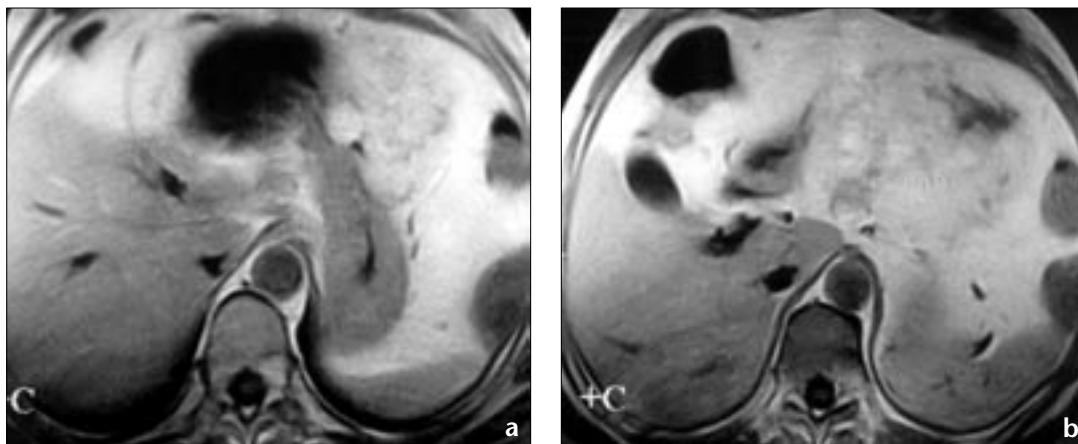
a, b. Focal extension into the gastric wall and significant contrast enhancement of the mass are seen on consecutive transverse post-contrast T1-weighted MR images.
